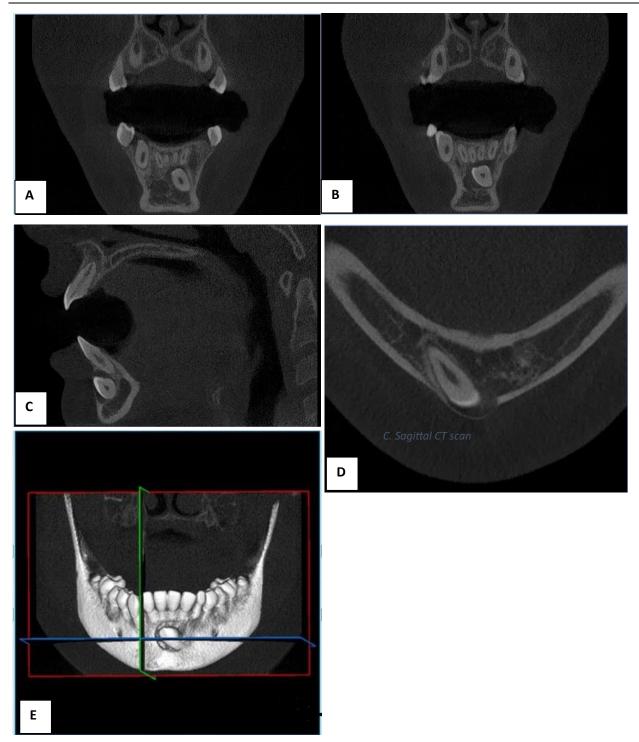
Pre-operative CT scan. A): axial CT scan; B): axial CT scan; C): sagittal CT scan; D): transverse CT scan; E): volumetric view CT.
